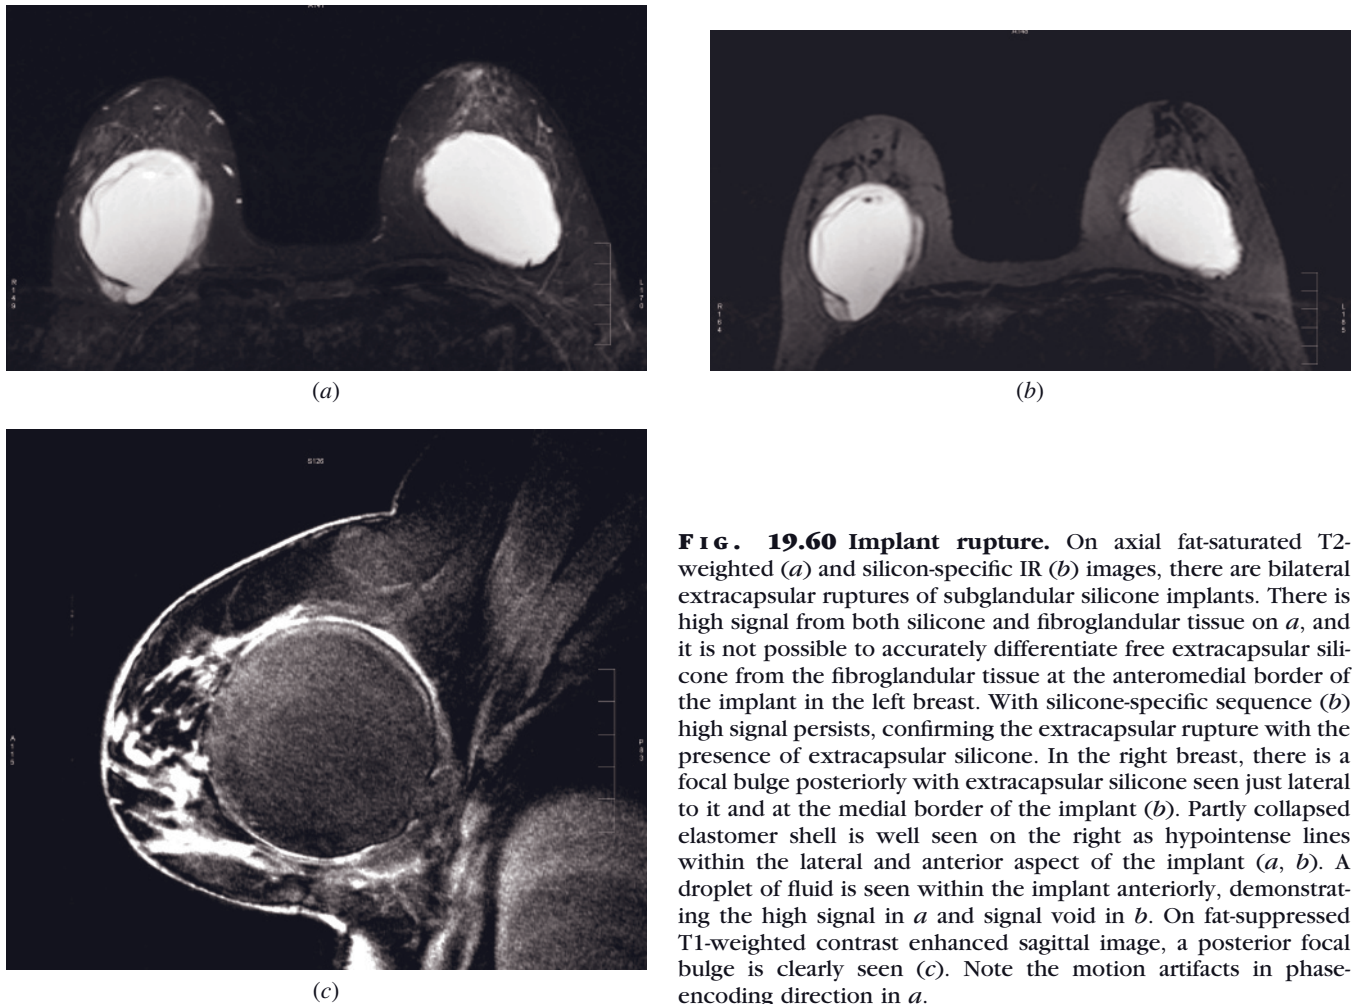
Implant rupture. On axial fat-saturated T2-weighted (*a*) and silicon-specific IR (*b*) images, there are bilateral extracapsular ruptures of subglandular silicone implants. There is high signal from both silicone and fibroglandular tissue on *a*, and it is not possible to accurately differentiate free extracapsular silicone from the fibroglandular tissue at the anteromedial border of the implant in the left breast. With silicone-specific sequence (*b*) high signal persists, confirming the extracapsular rupture with the presence of extracapsular silicone. In the right breast, there is a focal bulge posteriorly with extracapsular silicone seen just lateral to it and at the medial border of the implant (*b*). A partly collapsed elastomer shell is well seen on the right as hypointense lines within the lateral and anterior aspect of the implant (*a*, *b*). A droplet of fluid is seen within the implant anteriorly, demonstrating the high signal in *a* and signal void in *b*. On fat-suppressed T1-weighted contrast enhanced sagittal image, a posterior focal bulge is clearly seen (*c*). Note the motion artifacts in phase-encoding direction in *a*.
